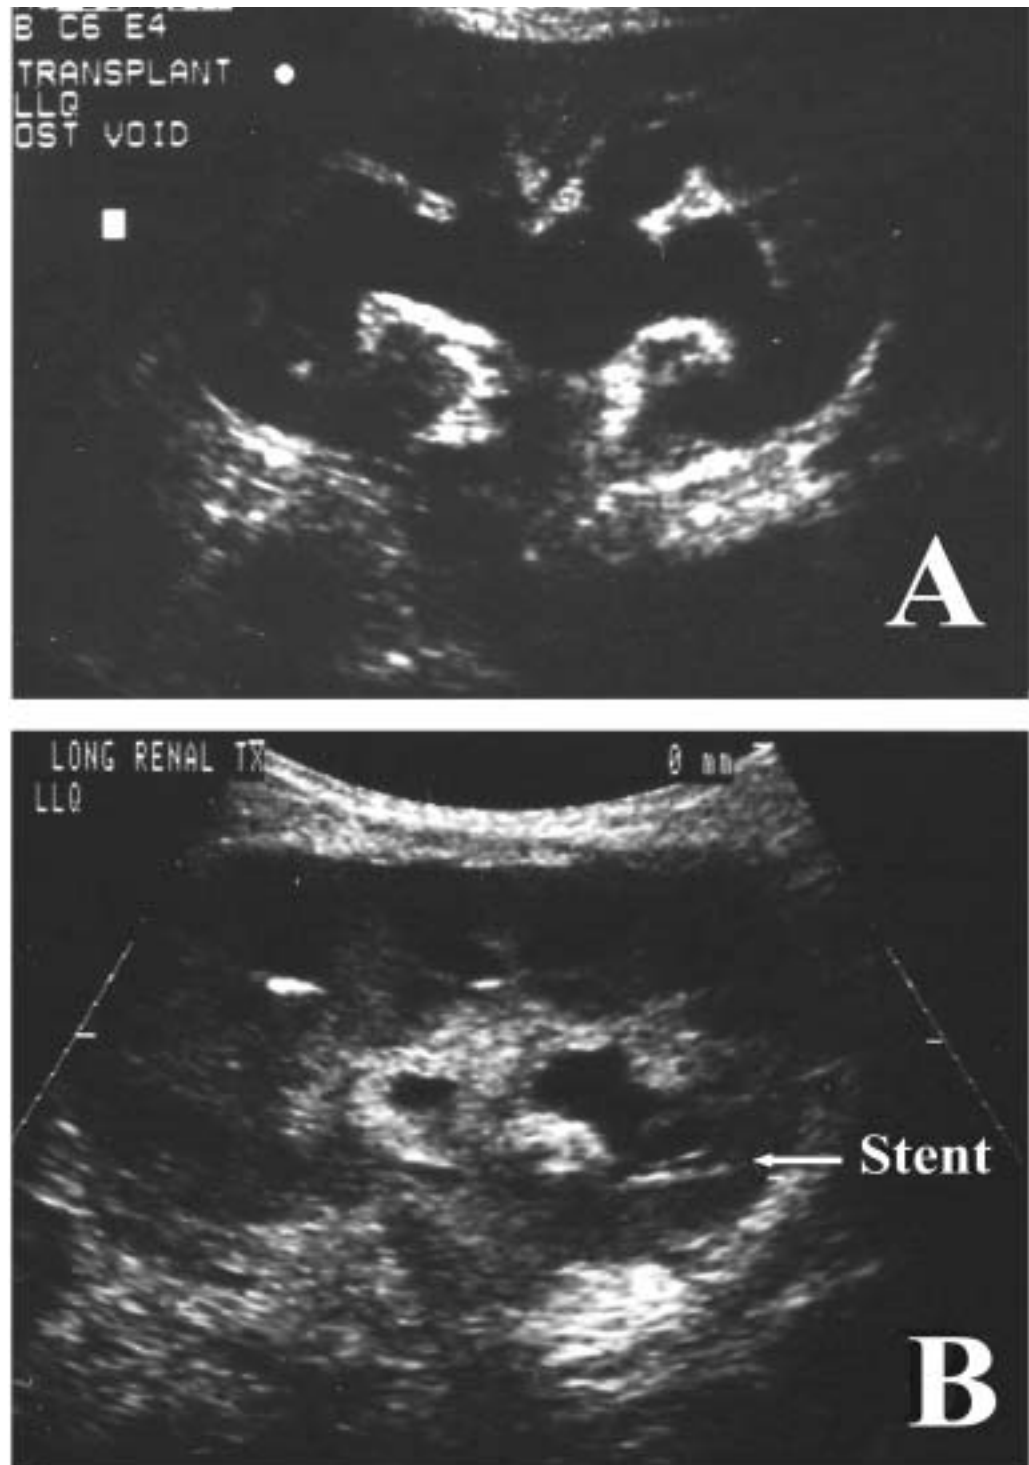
Extra-parenchymal complication in a patient (case 2) with posttransplant polyomavirus infection. Ultrasonogram of renal allograft reveals marked hydronephrosis in (A) and resolution after stent placement in (B).
